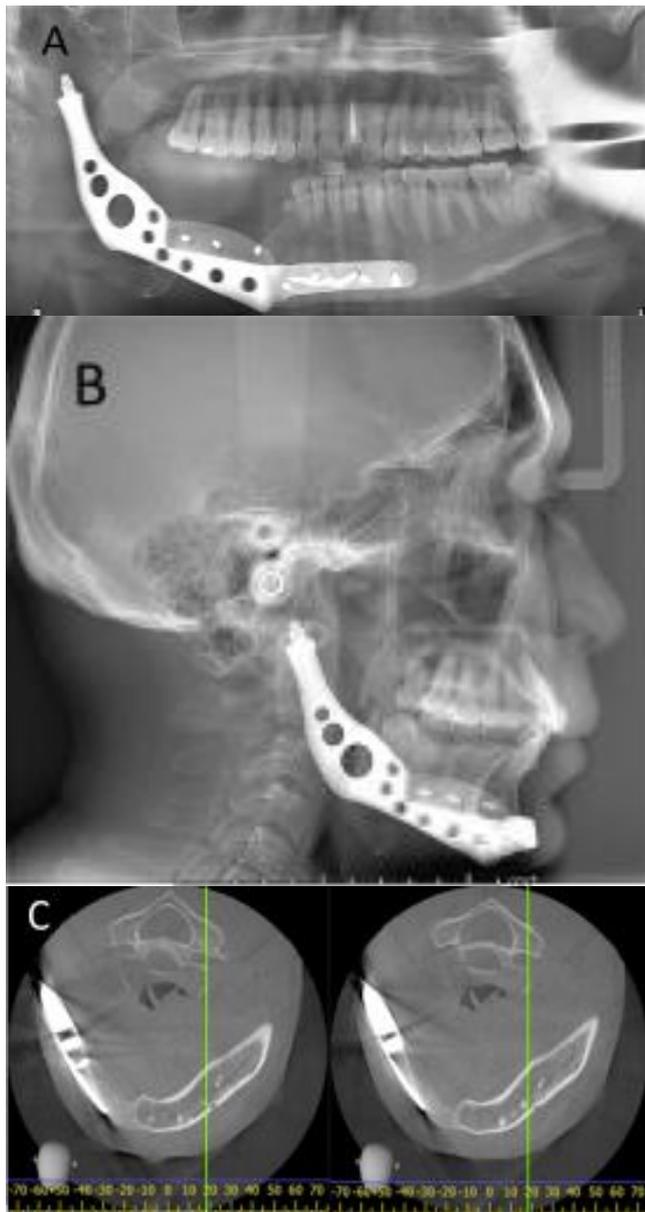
Radiograph showed mandibular prosthesis with condyle and a corticocancellous bone graft (arrow heads) was placed in planned position with no clinical complication after 3 months post-operatively. (A) Panoramic radiograph (B) Lateral cephalometric radiograph (C) Cone-beam computed tomography (axial views).
